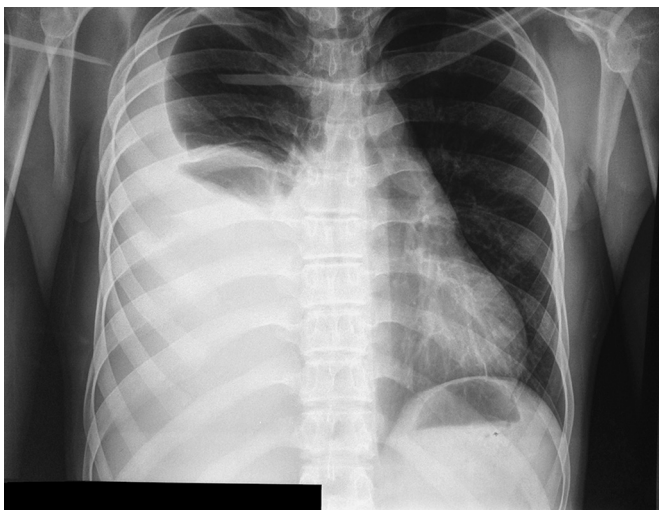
Initial Chest X-ray demonstrated a large right pleural effusion, that occupies 2/3 parties of the right hemithorax accompanied with fever and right chest pain.
